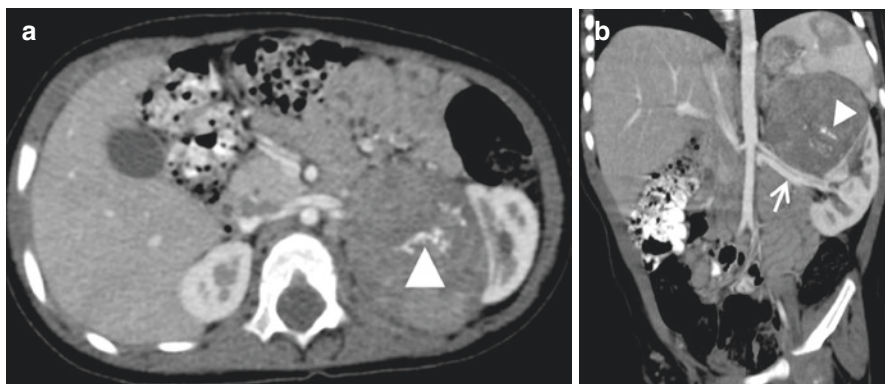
A 14-month-old boy with localized left adrenal neuroblastoma (MYCN non-amplified, segmental chromosome alterations, INSS stage 3, INRG L2). Contrast-enhanced transverse CT scan (a) and MPR coronal (b) views. The tumour demonstrates low central calcifications (arrow-heads) and moderate and heterogeneous enhancement. The mass displaces the upper pole of the left kidney and the renal pedicle (arrows)
